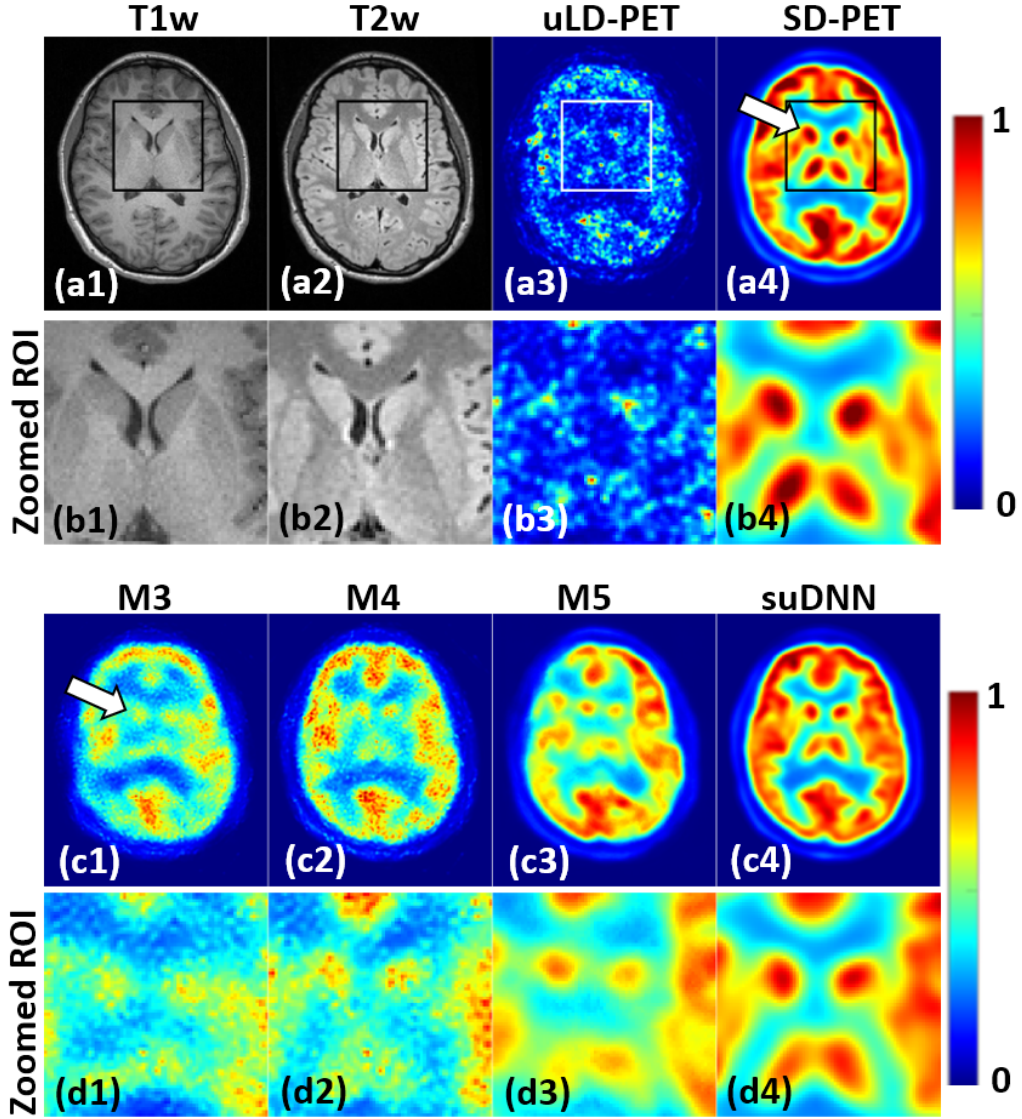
Visual inspection of the zoomed ROIs of the input, reference, and predicted images for the case of uLD-PET. (a1)–(a3): input T1w MRI, T2w MRI, and uLD-PET image images. (a4): reference SD-PET image. (c1)–(c4): predicted images from the methods M3–M5 and the proposed suDNN method. (d1)–(d4) corresponding zoomed regions.
